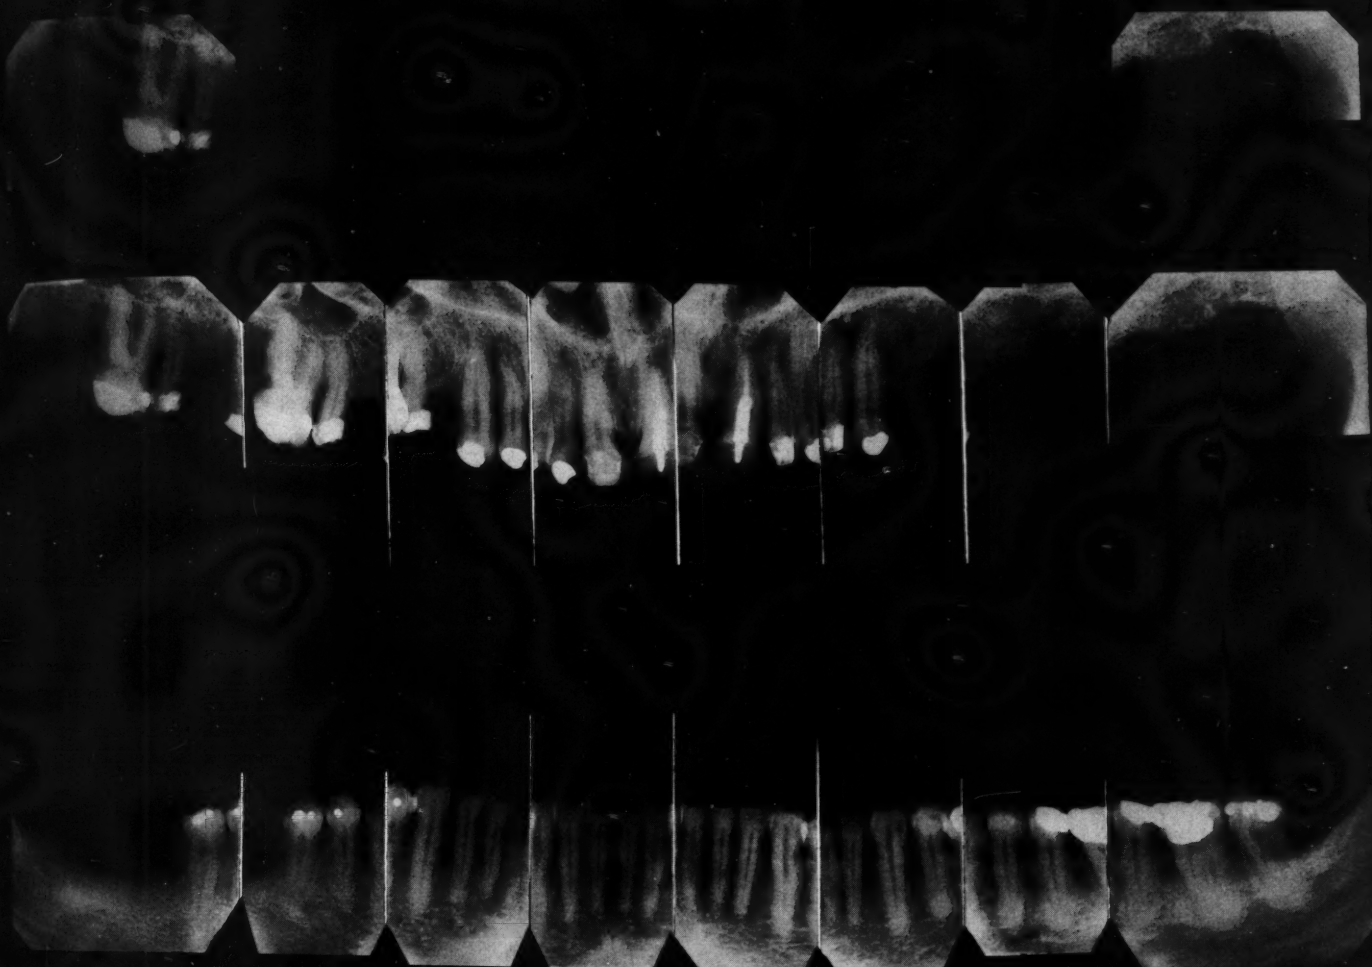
Full mouth roentgenogram. Technical factors: Film: Bolin, lightning speed. Distance: 25 inches. Milliamperes: 10. K. V. P.: 55. Time of exposure: Molars,  $3\frac{1}{2}$  seconds; bicuspids, 3 seconds; cuspids,  $2\frac{3}{4}$  seconds; lateral, 3 seconds; central, 3 seconds. (Exposure time is the same for the maxilla and mandible.) Time of development: 5 minutes. (The films in this set were cut down after drying.)
